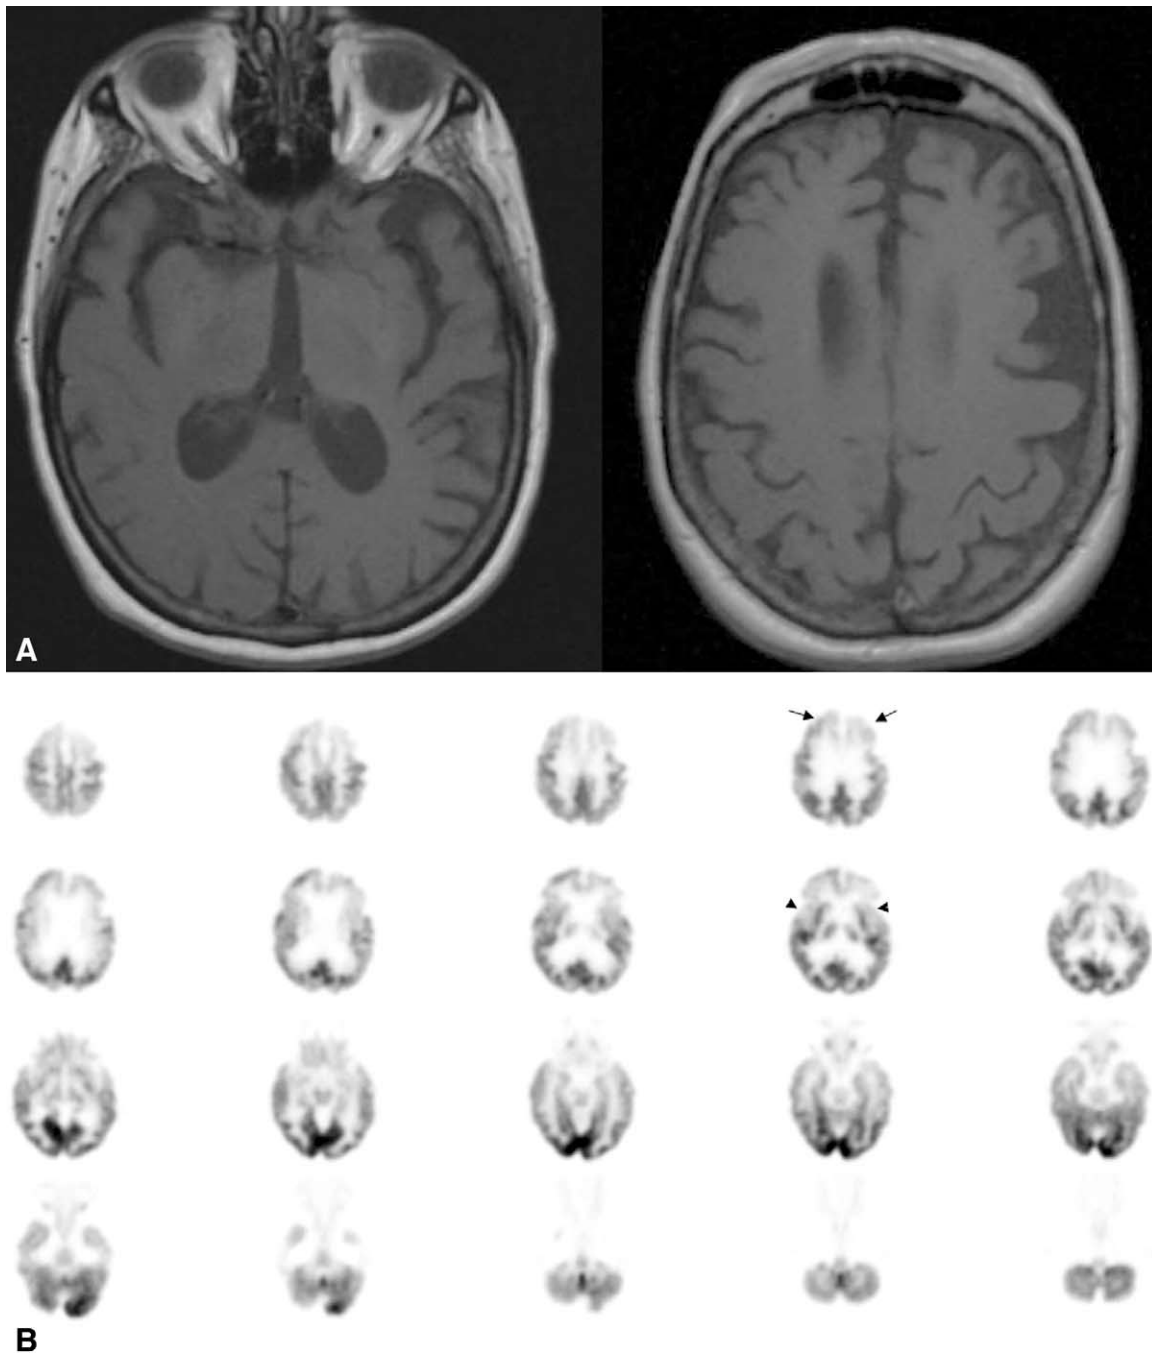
Frontotemporal dementia: A 62-year-old woman presenting with significant memory loss. (A) Magnetic resonance imaging performed 4 months before the PET study shows diffuse atrophy of the frontal and temporal lobes. (B-D) The positron emission tomography with 2-deoxy-fluoroglucose (axial, coronal, and sagittal planes) scan shows significant hypometabolism in the frontal and temporal lobes bilaterally (arrows) with relatively preserved glucose metabolism in the parietal and occipital lobes.
